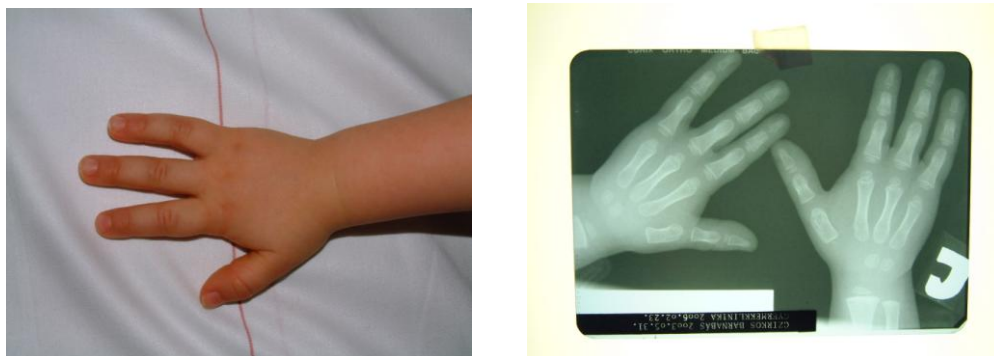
Photo and X-ray of the boy (3-year-old) hands
